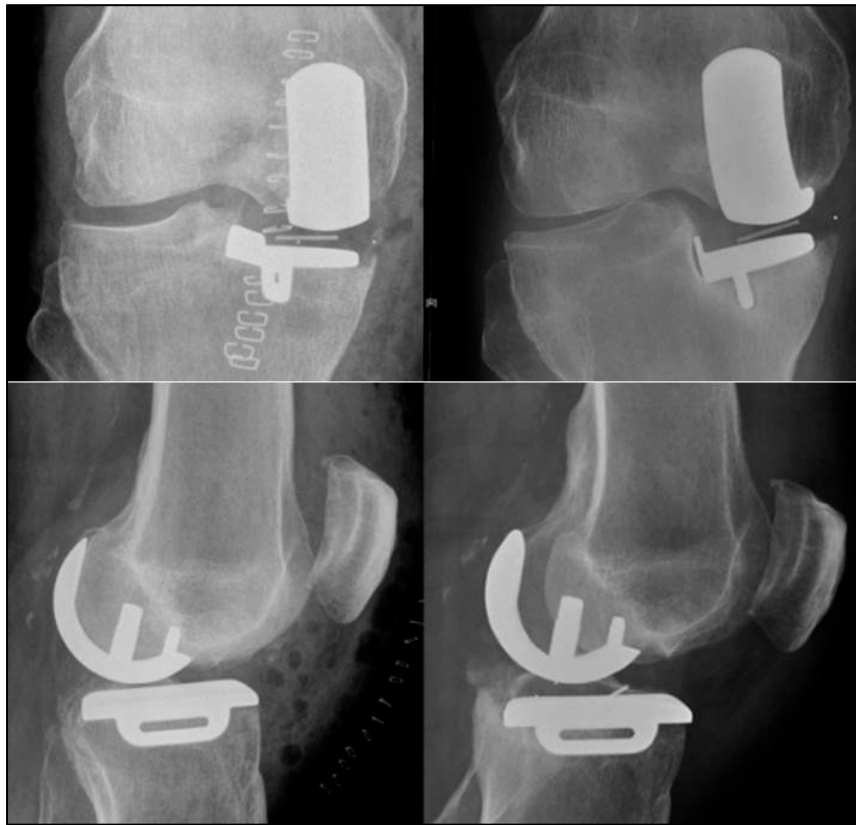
Radiographs of patient 4
